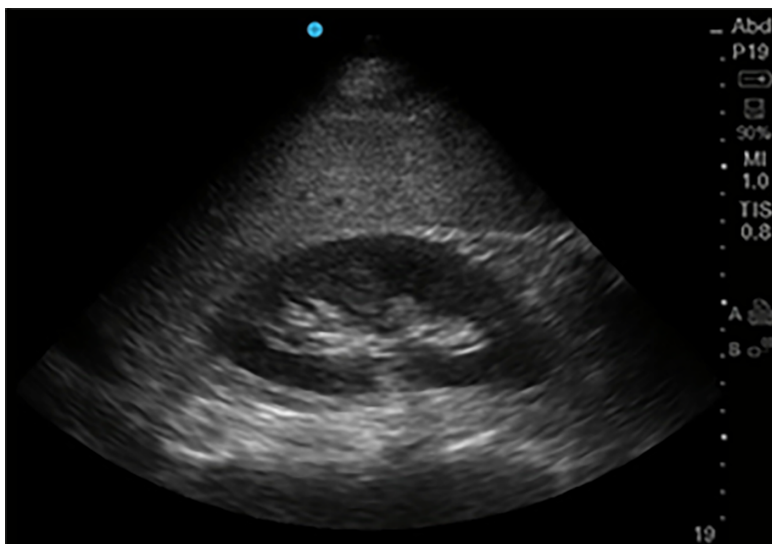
Kidney in its Longitudinal axis. Phased array probe (1-5 MHz) in “Abdominal” preset placed with probe marker facing cephalad in right mid-axillary location. In this normal ultrasound, the liver serves as an acoustic window, under which can be seen the thin hyperechoic kidney capsule, the hypoechoic parenchymal cortex, and the central hyperechoic renal sinus.
